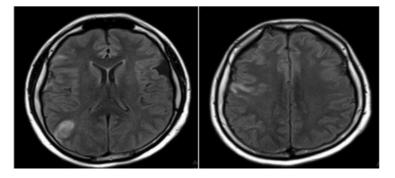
2. MRI image demonstrates FLAIR sequence with two hyperintense
